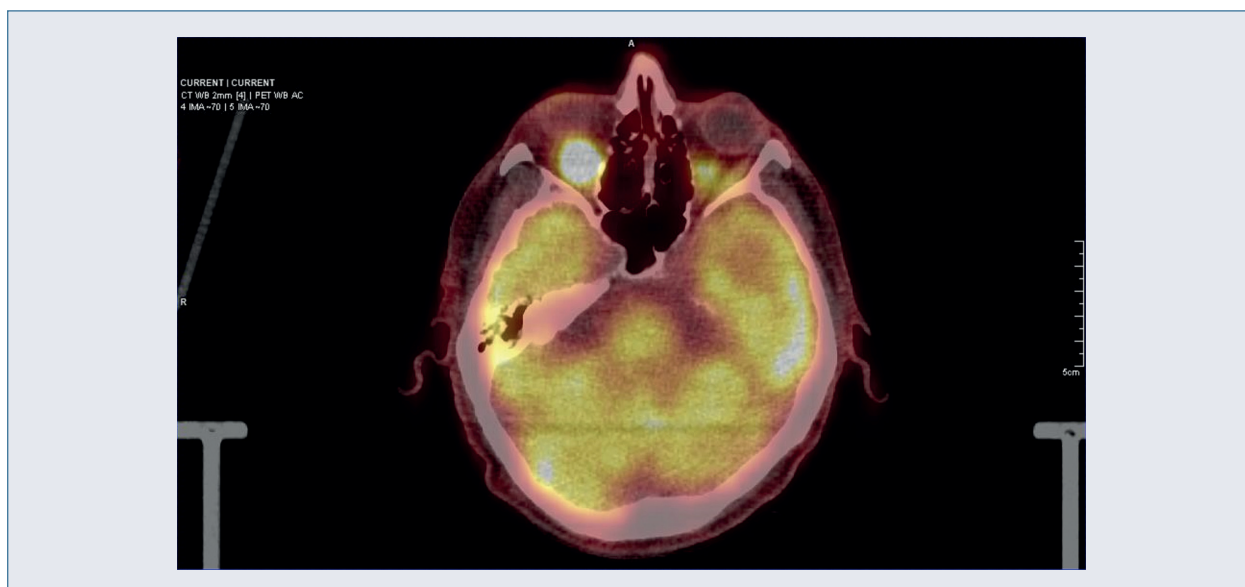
Positron emission tomography-computed tomography scan of head
